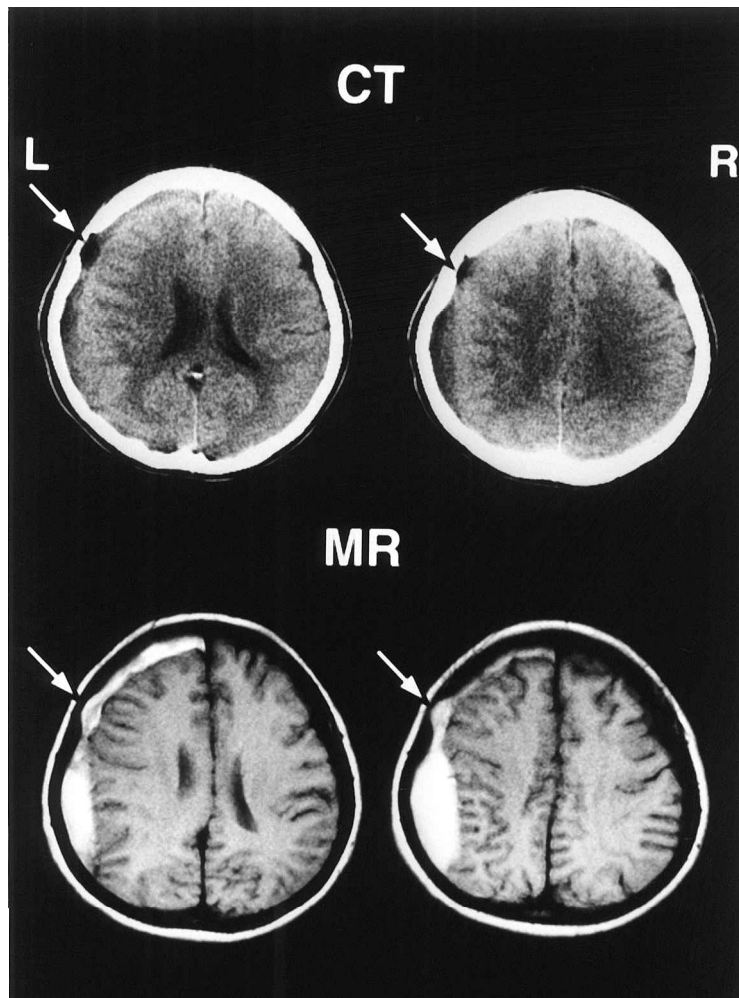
Patient 5. Upper: CT scans showing a low density subdural hematoma in the left frontoparietal region and a small arachnoid cyst with an adjacent bony indentation in the left frontal convexity (arrow). Lower: MR images revealing the presence of blood in the arachnoid cyst (arrow).
